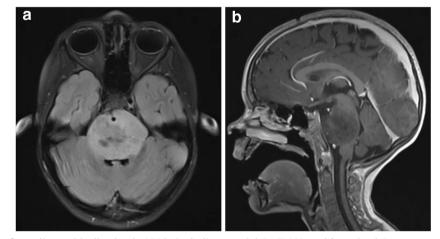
MRI images of a radiographically classic DIPG, including a axial T2 FLAIR and b sagittal T1 post-contrast images. Diffuse enlargement of the ventral pons and encasement of the basilar artery are classic signs.
